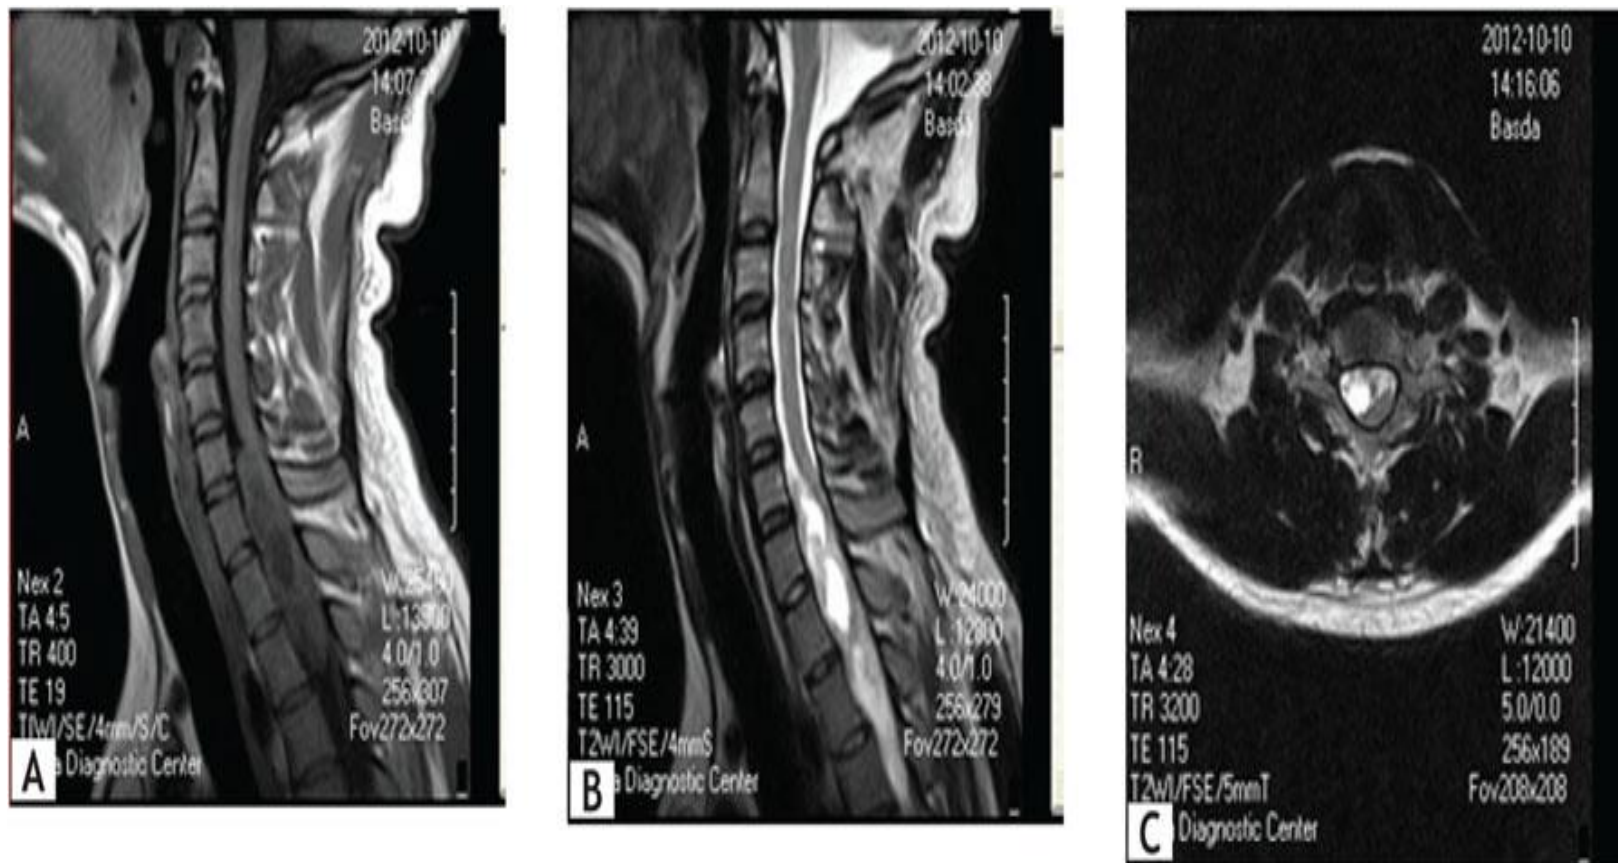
MRI cervical spine magnetic resonance imaging (a) Sagittal T1WI & T2WI sequence demonstrates hypointensity in T1WI and heterogeneously T2WI hyperintense intramedullary mass extending from C2-C4 spinal segments. (b) Enhanced T1-weighted sequence demonstrates nearly homogeneous mass enhancement. Pathology was consistent with schwannoma.
